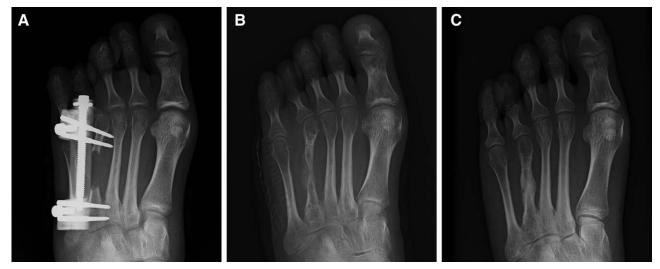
Anteroposterior view, radiograph. A, After a 7-mo consolidation period. Note that the regenerative bone does not have sufficient thickness and resembles an hourglass. B, Intraoperative view immediately after removing the distractor and grafting of HA/Col. C, 6 months after the second surgery. Note the sufficient thickness of the metatarsal.
